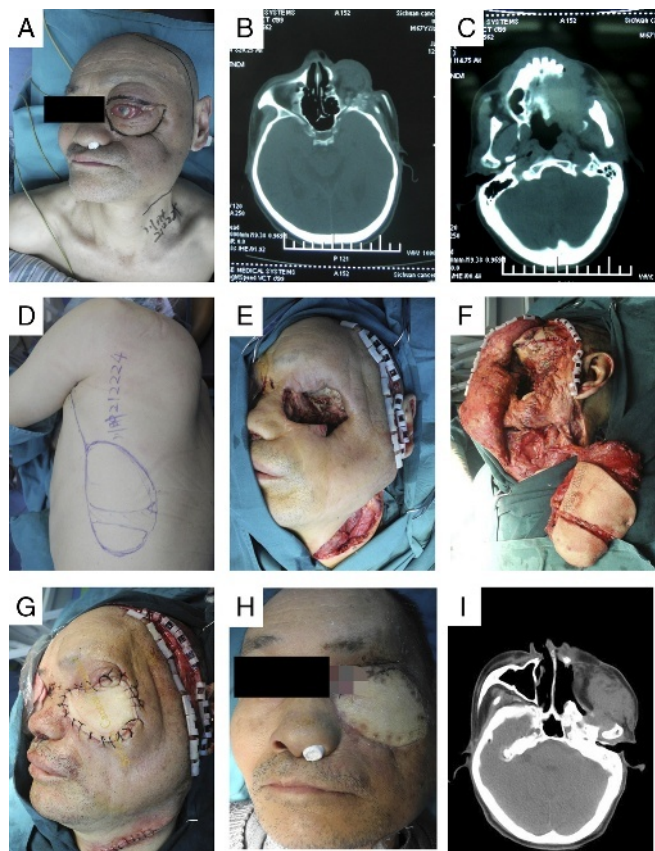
A 65-year-old man presented with recurrent, poorly differentiated squamous cell carcinoma of the maxillary sinus after surgery and radiation therapy. A, Preoperative image. B and C, The computed tomographic appearance of the lesions. D, The design of 2 segmental latissimus dorsi flaps. E, Defect after removal of the tumor. F, The flap was anastomosis end to end with superior thyroid artery and vein. G, Immediate photograph after the reconstruction. H, Postoperative image after stitches removal. I, The computed tomographic image 2 weeks after the reconstruction.
